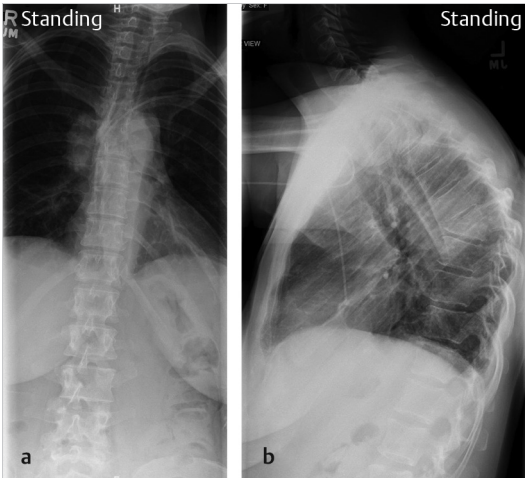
Anteroposterior (a) and lateral (b) X-rays of the thoracic spine with kyphotic deformity centered about T7 and T8.
